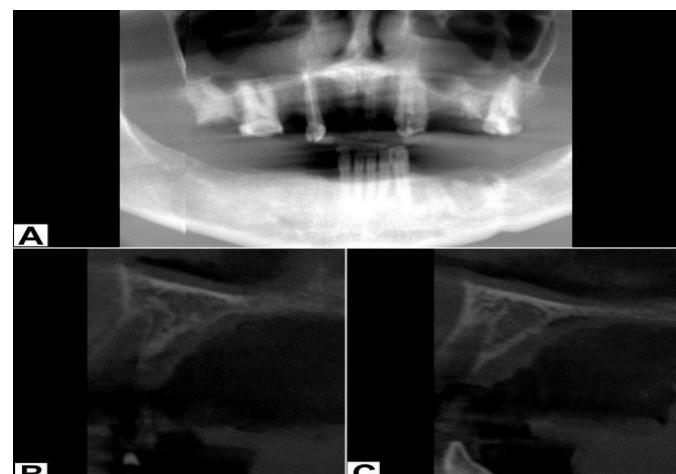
CBCT sections taken immediately after tooth extraction of left and right upper lateral incisors, A: A panoramic view, B: A cross-section view for the socket of the upper right lateral incisor, C: A cross-section view for the socket of the upper left lateral incisor.
